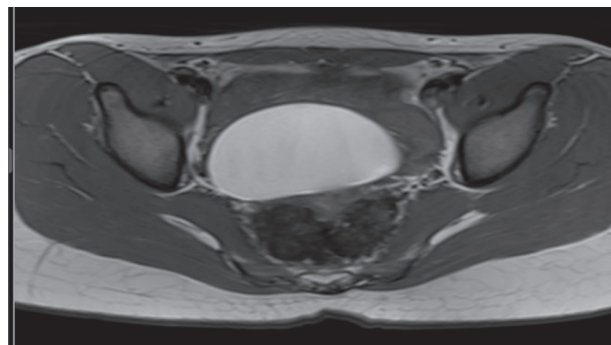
T1 Weighted MRI, Axial View
